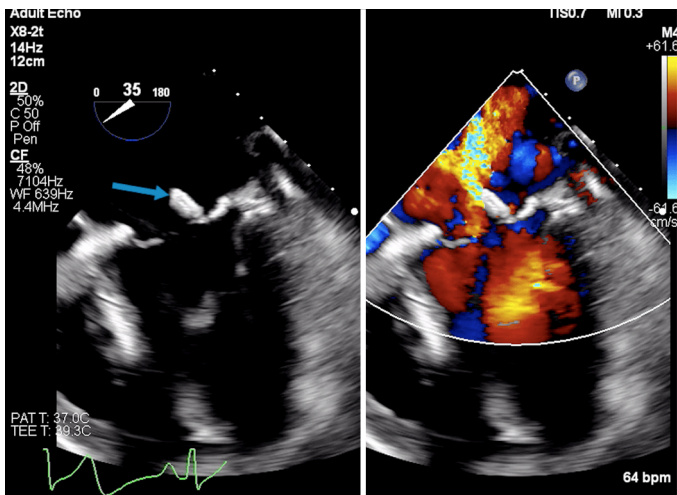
Transesophageal echocardiogram in mid-esophageal level at 35° showing a mobile vegetation on the anterior mitral valve leaflet (blue arrow) and significant mitral regurgitation.
